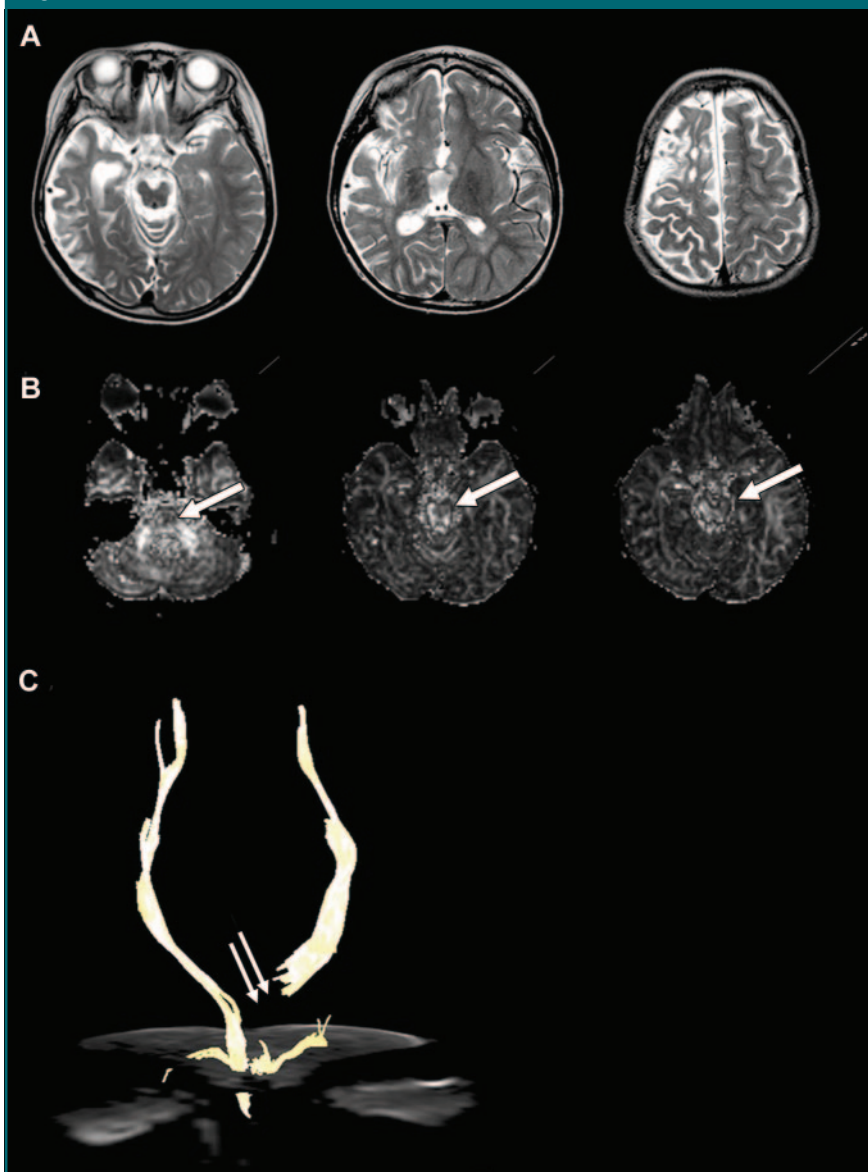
Images in 7-year-old boy involved in a vehicular accident 3 years before and suffering from intractable seizure. Electroencephalography demonstrated persistent discharge of epileptic wave in the right hemisphere. Functional right hemispherectomy was planned for treatment of the intractable seizure. However, patient demonstrated right-side hemiplegia instead of left-side dysfunction. *A*, Transverse T2-weighted (4000/100; matrix, 352 × 352; FOV, 230 × 230 mm; section thickness, 5 mm) images show cerebromalacia of right hemisphere and atrophy. Precentral gyrus is relatively spared. *B*, Fractional anisotropy maps show lack of high signal intensity of longitudinal pontine fiber tracts in the left-side cerebral peduncle, suggesting axonal injury (arrows). *C*, Fiber tractography with superimposed transverse *b0* image shows cutting off of left corticospinal tract at the level of left cerebral peduncle due to axonal injury (arrows). Right corticospinal tract is intact although atrophy and cerebromalacia are demonstrated in the remainder of the brain. Callosotomy was performed instead of functional hemispherectomy on the basis of DT and fiber tractography findings, because right hemispherectomy would have resulted in quadriplegia (DT imaging: 32 directions; six-channel sensitivity encoding; sensitivity encoding factor of two; *b* value, 600 sec/mm²; 6599–8280/70; matrix, 96 × 96; FOV, 220 × 220 mm; section thickness, 2.3 mm).
